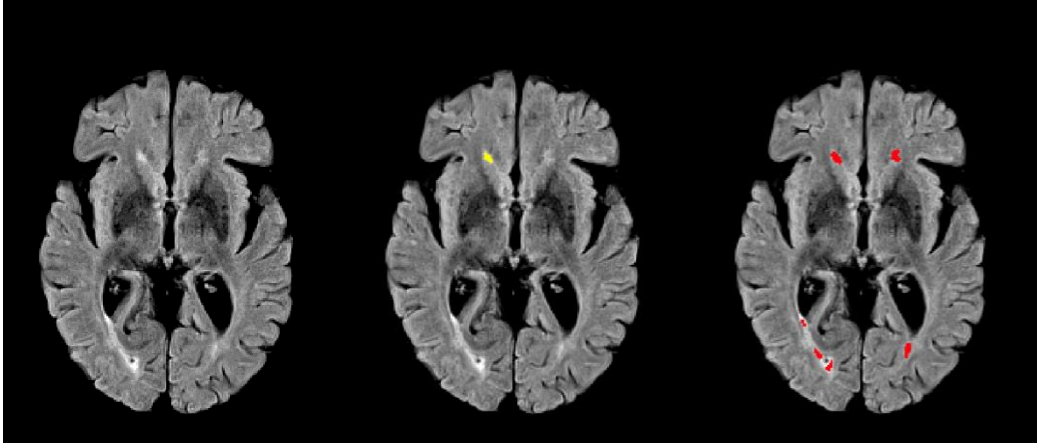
Visual example of the difference existing between “preliminary” (central panel – yellow area) and “expert” (right panel) segmentations, outlined on a FLAIR image (left panel – red area).
